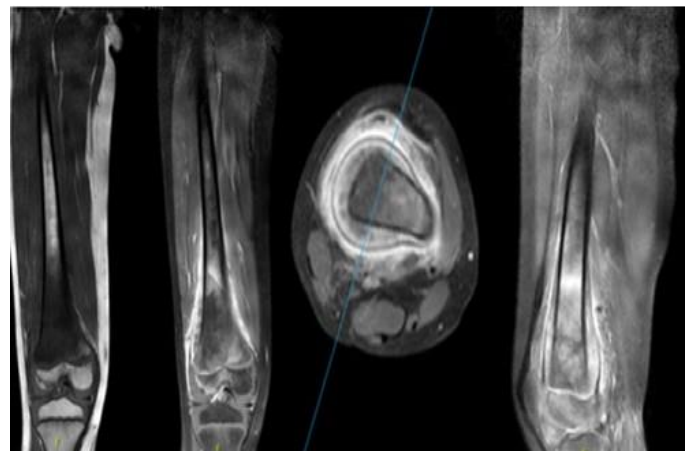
Magnetic resonance imaging (MRI) showing a metaphyseal lesion with low T1 signal and high T2 signal associated with a soft-tissue mass
